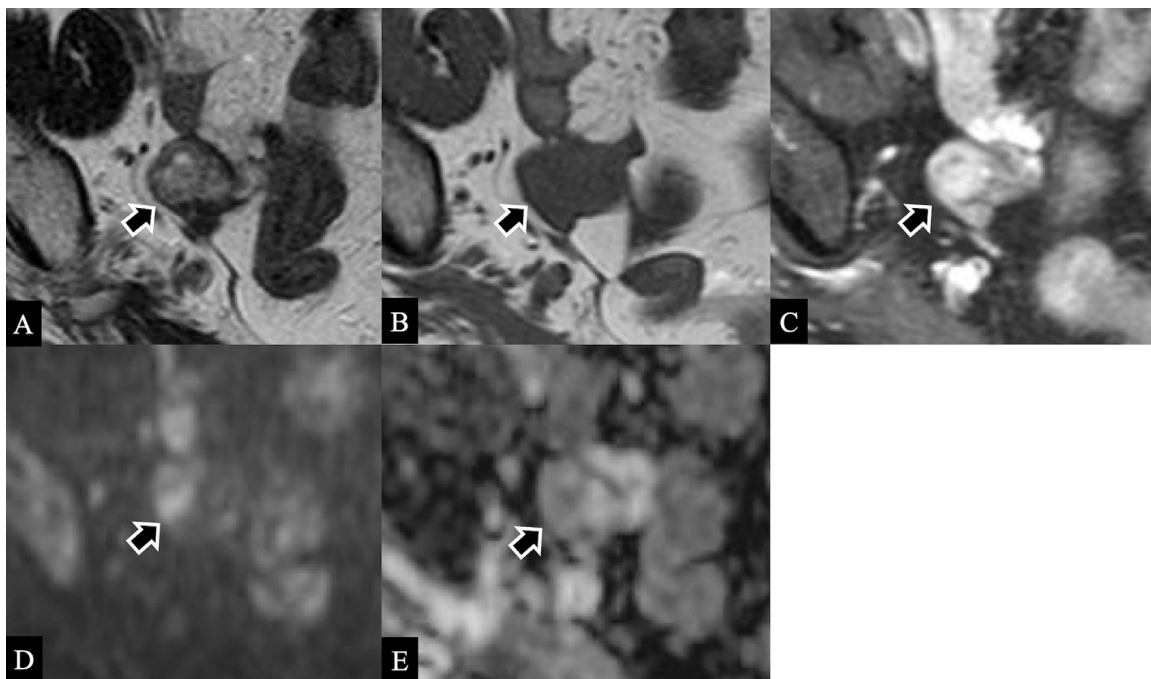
Magnetic resonance images of the ovarian metastasis were obtained 9 months after detection. The mass demonstrates heterogeneous signal intensity, mostly low and partially high signal intensity on T2-weighted image (A) implying the existence of degeneration or necrosis, low signal intensity on T1-weighted image (B), high signal intensity on diffusion-weighted image (D), and low apparent diffusion coefficient value ($0.85 \times 10^{-3} \text{ mm}^2/\text{s}$) (E). The tumor is generally well-enhanced and small degenerative areas are also observed on contrast enhanced fat-suppressed T1-weighted image (C)
